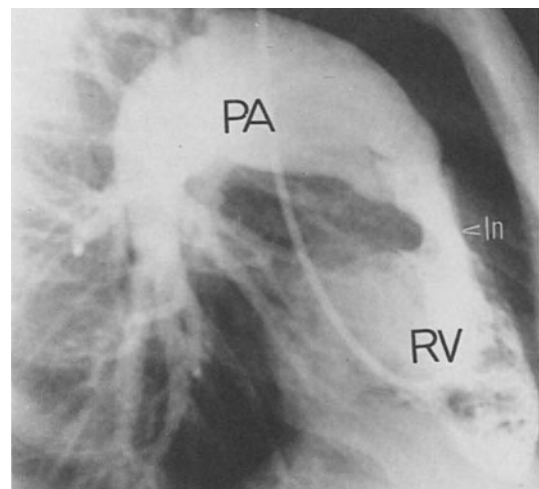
Chest X-ray in pulmonary valve stenosis demonstrating an enlarged main pulmonary artery that is a result of poststenotic dilatation seen
